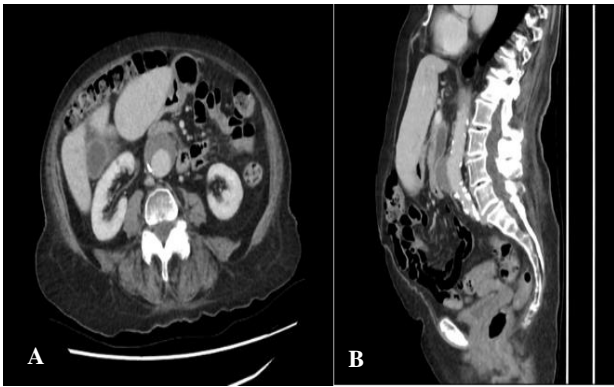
(A and B): CT chest, abdomen, and pelvis: proximal common bile duct dilation secondary to extramural thrombus of abdominal aortic aneurysm.
